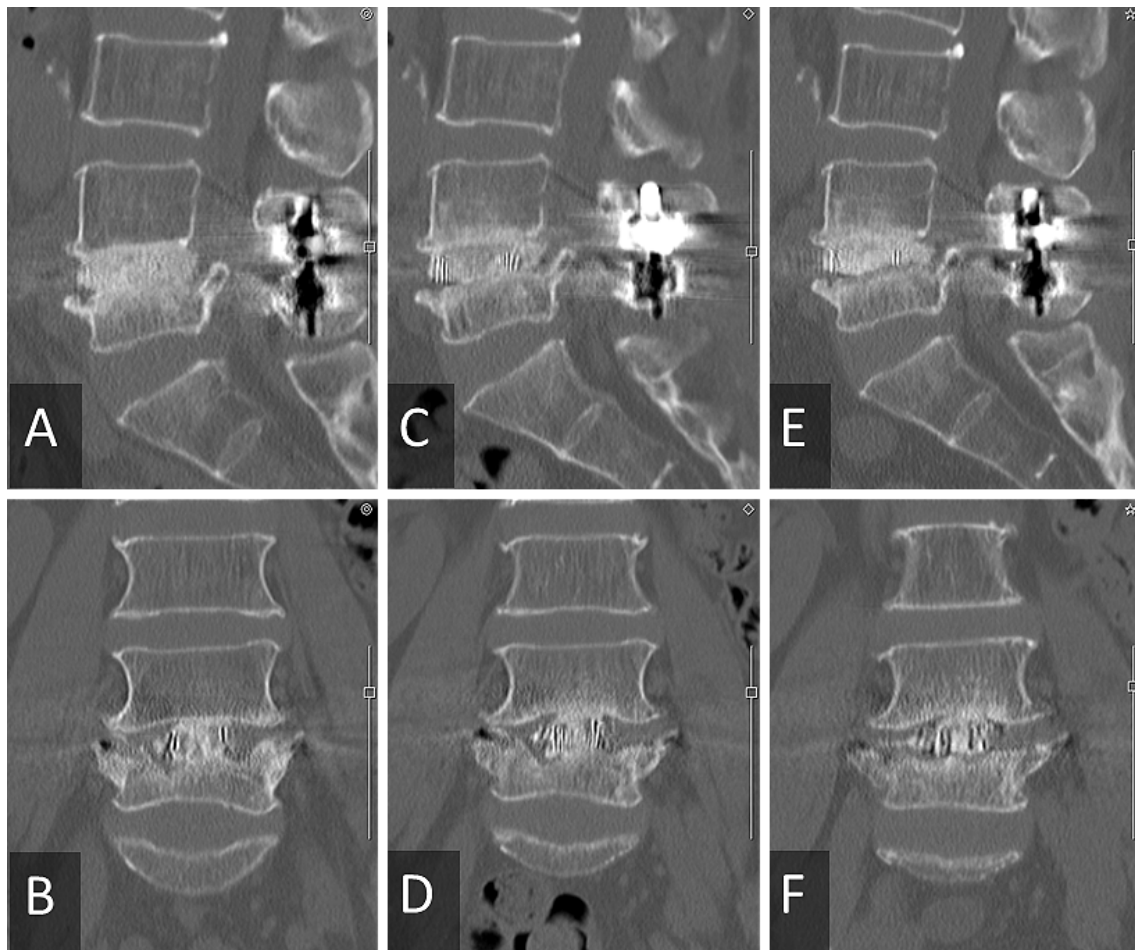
Sagittal and coronal CT of L4/5 PLIF in a 70-year-old woman. Panels A and B: 2 months postoperatively; C and D: 4 months postoperatively; E and F: 6 months postoperatively. Bony union at 2 and 4 months was reassessed as nonfusion at 6 months.
